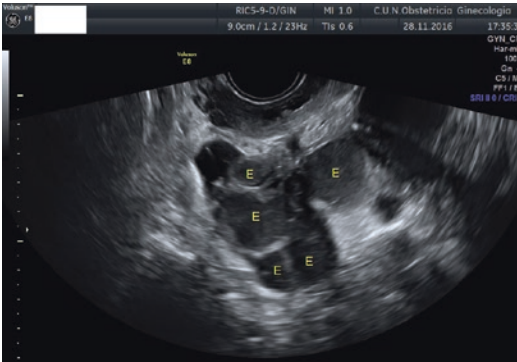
Transvaginal ultrasound showing an ovary containing multiple small endometriomas (E)
